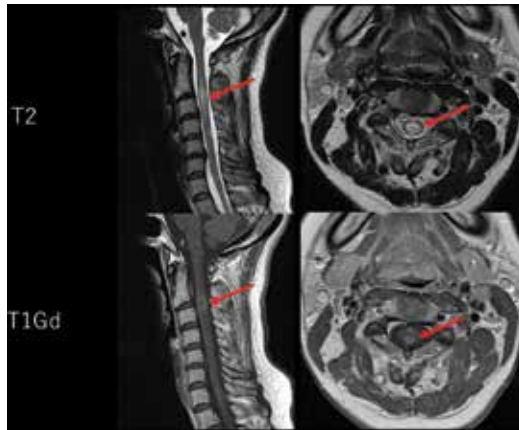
Spinal MRI of the multiple sclerosis patient. T2: T2 weighted image; central cord lesion in C2-C4 (arrow). T1 Gd: T1 weighted gadolinium enhancement; mild enhancement of C2-C3 lesion (arrow).
